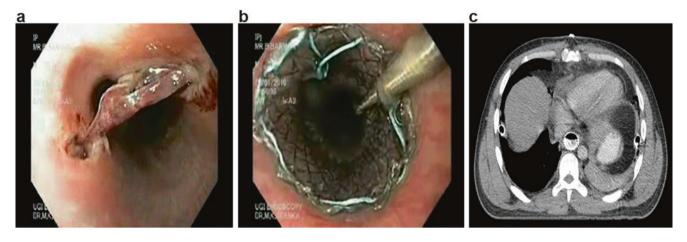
Esophageal traumatic fistula. (a) Endoscopic image of two esophageal fistulae. (b) Fistulous opening closed by fully covered metal stents. (c) CT image showing fistulae closed by stent
